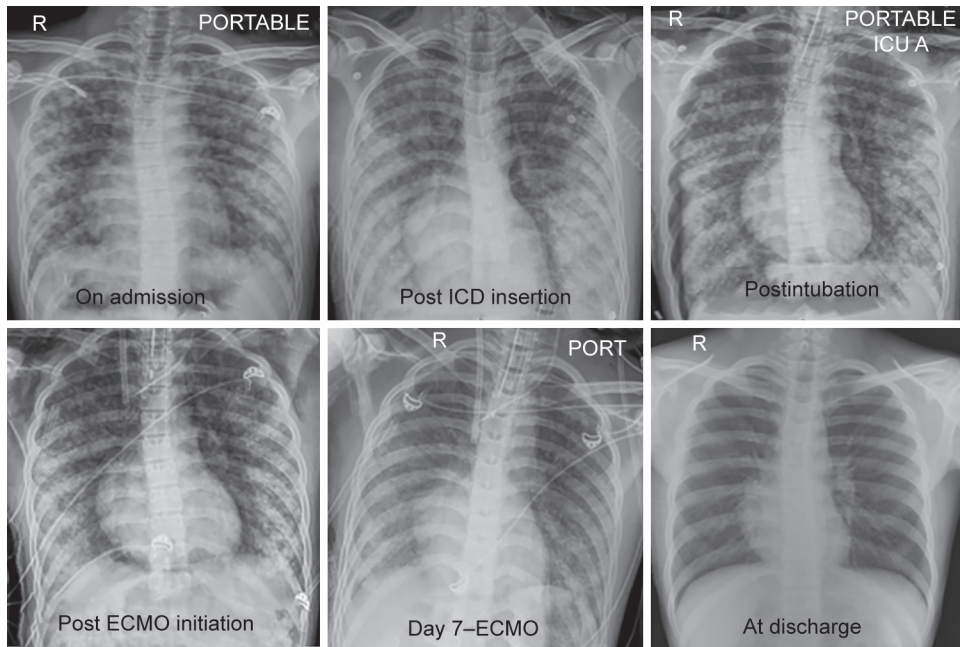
Evolution of chest X-ray in patient 1
